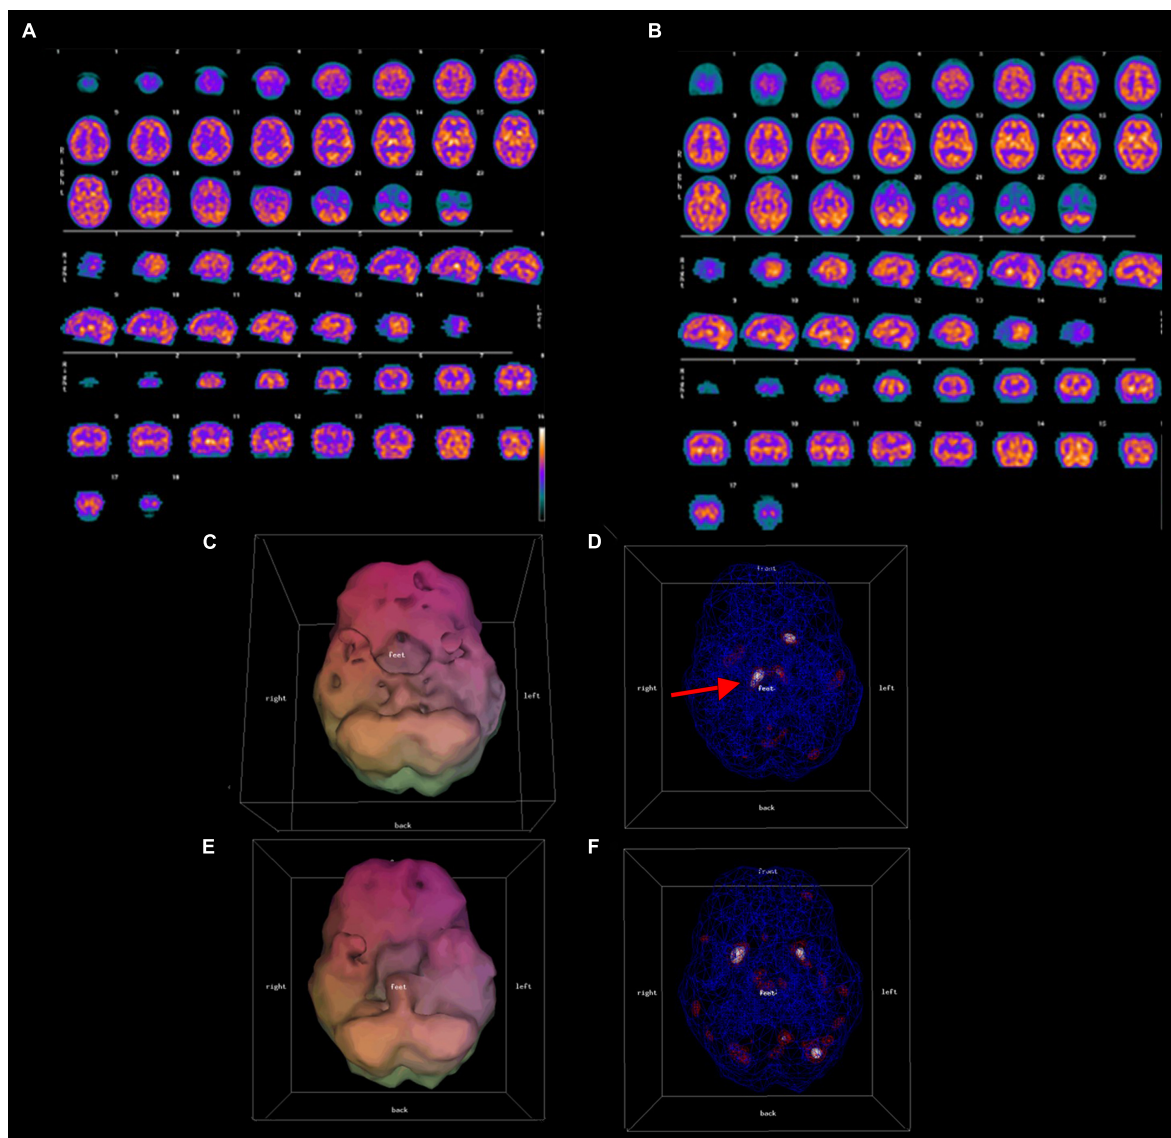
Conventional (A,B) and 3D thresholded (C–F) displays of pre-treatment (A,C,D), and post-treatment (B,E,F) SPECT scan results for one representative patient. A 49 year old male with symptoms of ADHD and mood dysregulation underwent a SPECT scan. Both conventional (A) and 3-D thresholded SPECT displays (C,D) prior to treatment show diffuse cortical hypoperfusion most severe in the bilateral temporal lobes and the orbitofrontal cortices, as well as over-activity of the thalamus [red arrow in panel (D)]. Post-treatment scans (B,E,F) show improved temporal, dorsal frontal, and parietal lobe perfusion, normalization of thalamic perfusion, and a reduction of hypoperfusion in the orbitofrontal cortices.
